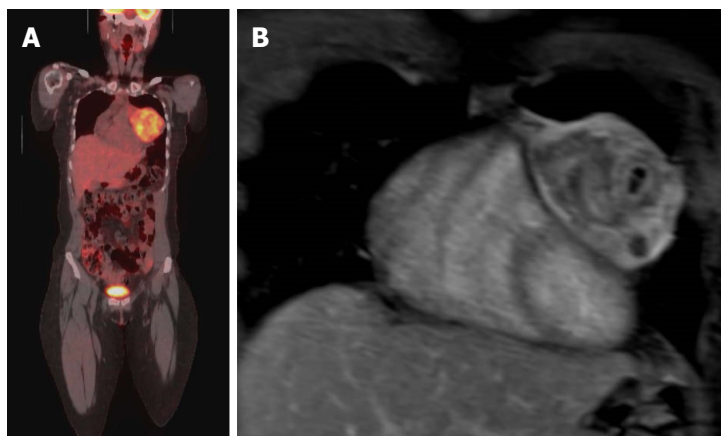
Evaluation of the aggressiveness of the lesion and assessment of cardiac involvement. A: Evaluation of the aggressiveness of the lesion and assessment of cardiac involvement; Coronal PET-CT image in a patient with Ewing sarcoma of the left chest wall with direct compression of the left side of the heart; B: Coronal Post contrast T1-weighted image of the heart shows no evidence of cardiac invasion with clear separation of the mass from the heart, the mass was surgically removed and there was no evidence of cardiac invasion. PET: Positron emission tomography; CT: Computed tomography.
